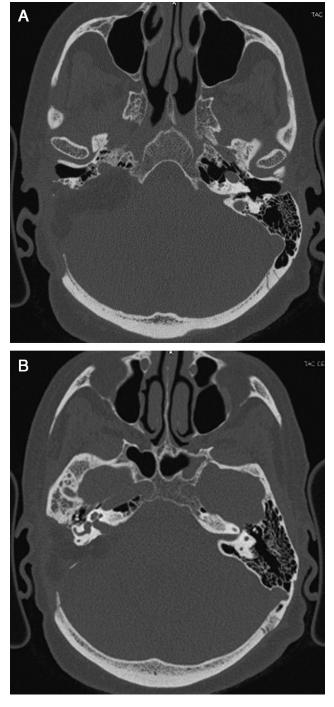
Postoperative axial HRCT scans with bone window of a tumor (case 4) managed with a petro-occipital transigmoid (POTS) approach. Notice the extent of the bone removal medial to the jugular foramen (A) and the preservation of the hearing system obtained using the POTS approach (B).
